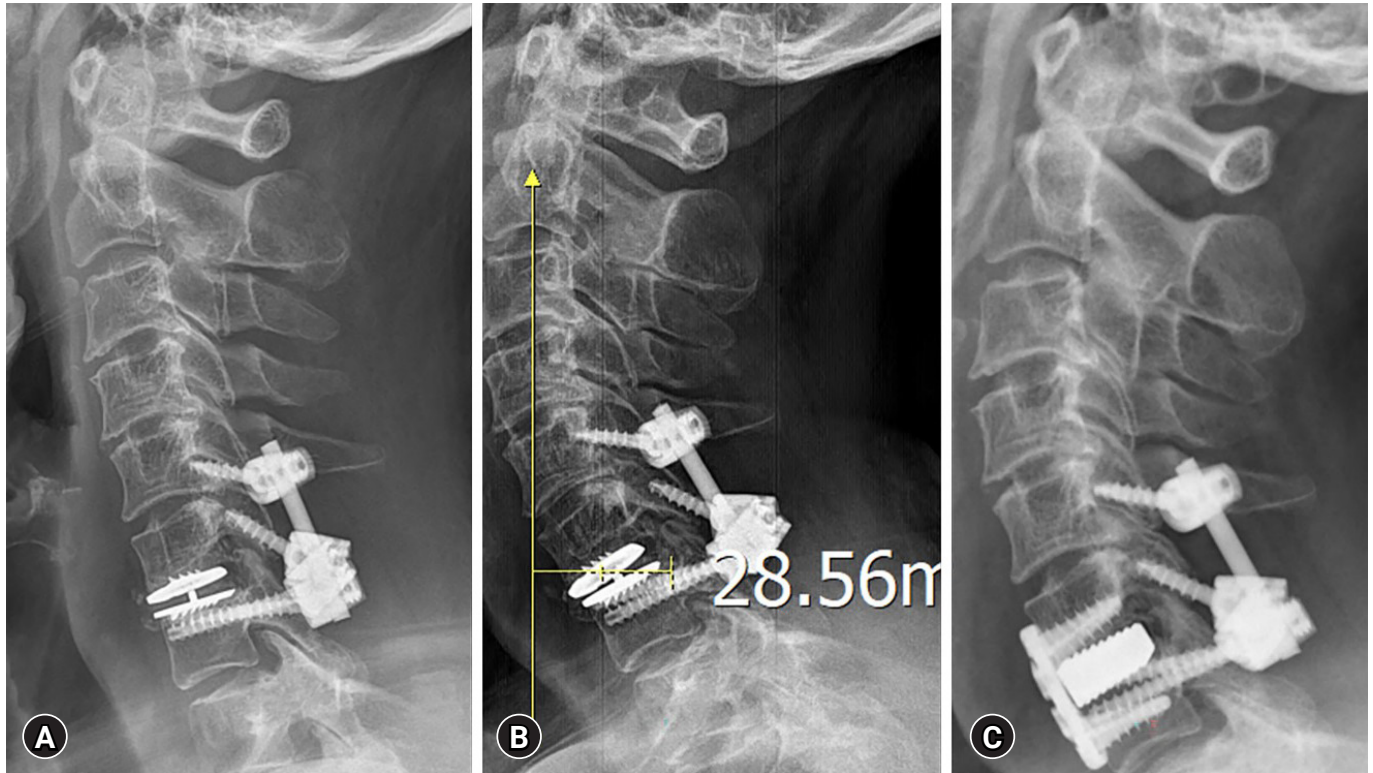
An immediate postoperative radiograph after the initial posterior decompression and fixation procedure (A). Due to the dorsal cortical bone manipulative violation during the screw insertion over the left side of the C6 lateral mass, the surgeon was obliged to shift the fixation level to the cranial level. The progression of kyphotic cervical alignment propagating from the flexed conformation of the Mobi-C device was manifested prominently on a lateral radiograph from follow-up a couple of months after initial surgery. The sagittal vertical axis distance exceeded 28 mm (B). A plain lateral-view after the secondary conversion to solid anterior cervical fusion with full removal of the causative mobile device revealed an immediate correction of the cervical kyphotic curvature (C).
